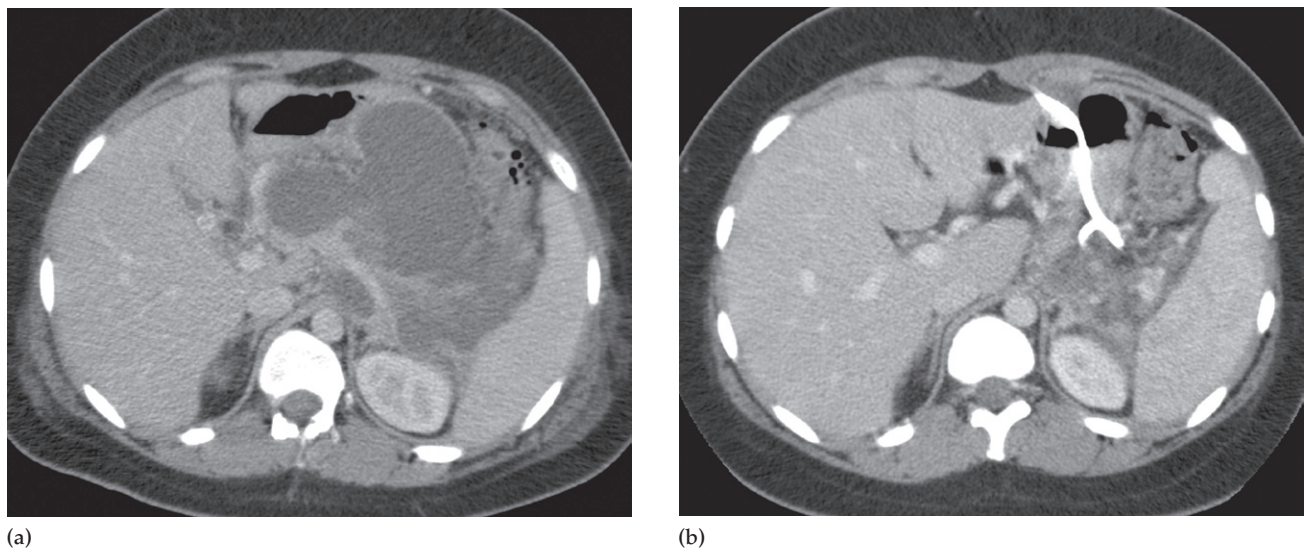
Pancreatic pseudocyst drainage. (a) CT scan showing a collection involving the body of the pancreas, which developed following acute pancreatitis. (b) A drainage catheter has deliberately been inserted through the stomach into the collection (to encourage the development of an internal rather than a cutaneous fistula), which has decreased significantly in size.
